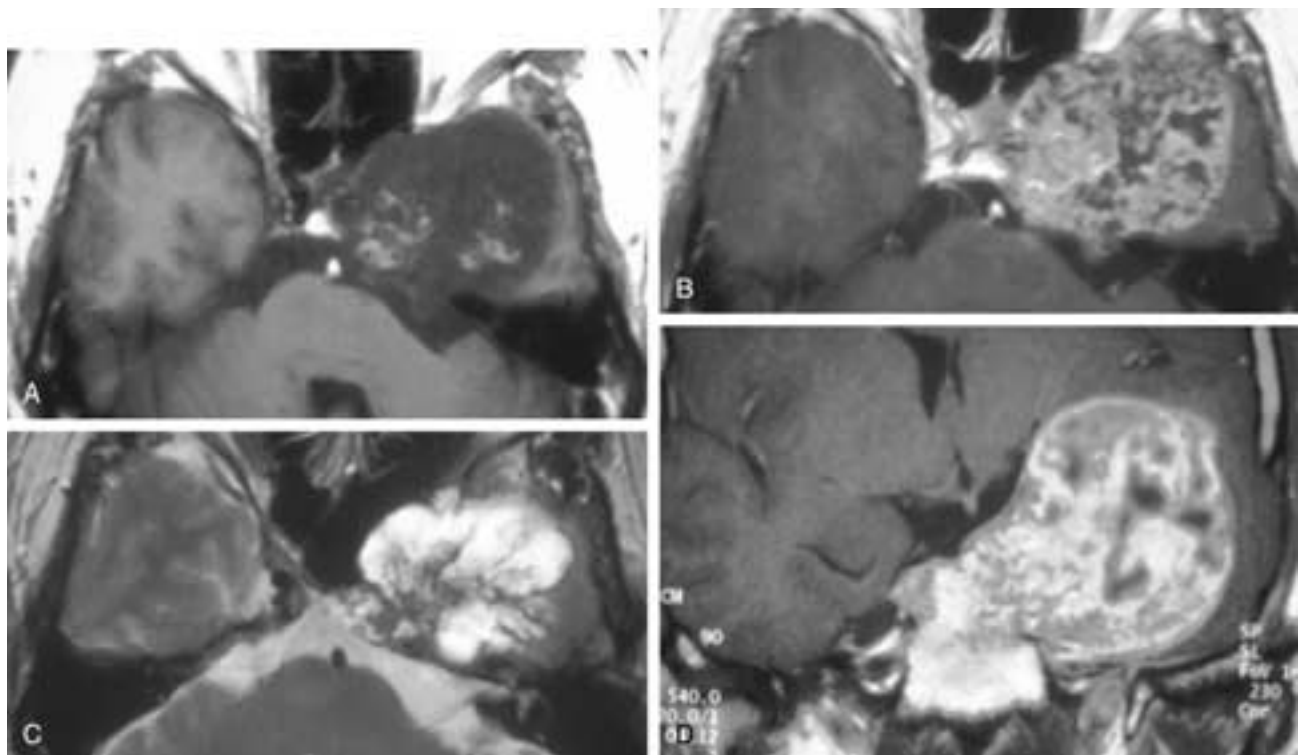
Skull base chondrosarcoma. A and B, T1-weighted pre- and postgadolinium images. C, Axial T2-weighted image. D, Coronal T1-weighted image after gadolinium enhancement.
